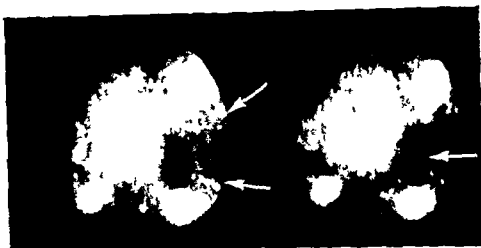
Lateral second scintigrams of a 34 year old female suffering from acute occlusion of the left middle cerebral artery. The image on the left was obtained 16—20 seconds after injection of ^{133}Xe into the left internal carotid artery the other image between 26—30 seconds after injection. Perfusion is normal in the area supplied by the pericallosal artery but is nearly absent in the area supplied by the middle cerebral artery (arrows left view). Radioactive markers identify the outer canthus and external auditory meatus. On both scintigrams the dark linear artifact (arrow right view) extending vertically from the latter marker was caused by focal oversaturation of the system.
